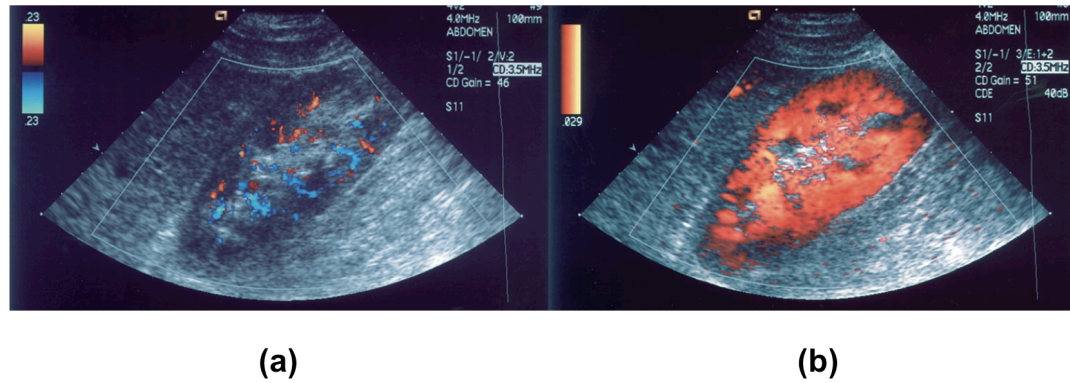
Sample Doppler color flow images of human right kidney using (a) color Doppler display mode showing only large vessels and (b) power Doppler mode with higher sensitivity showing the full cortical perfusion network [Downloaded from *Power Doppler Sonography, GE Healthcare, Medical Diagnostics: Medcyclopaedia.com* according to the term of use attached in Appendix A].
